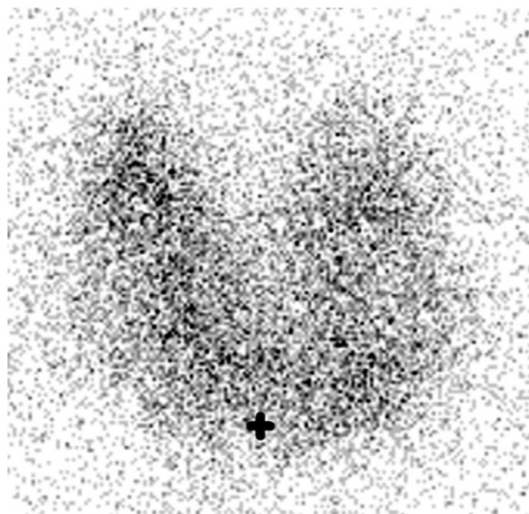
Thyroid scanning (performed with ^{99m}Tc -pertechnetate) in toxic multinodular goiter. Thyroid ultrasound scan is also useful in measuring the size of the goiter. Moreover, relative to radionuclide scanning images, it is helpful in identifying cold nodules. Fine needle biopsy should be performed in any palpable dominant nodule that is cold at scan.
